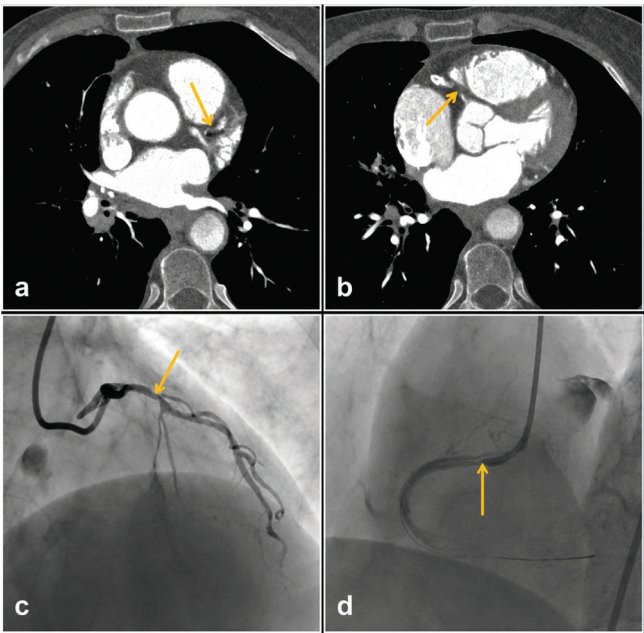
The thoracic computed tomography angiography image shows significant stenosis in the proximal left anterior descending (LAD) artery (a) and total occlusion in the right coronary artery (RCA) (b). Conventional coronary angiography image shows 70% stenosis in the LAD artery (c) and 90% stenosis in the RCA (d)
